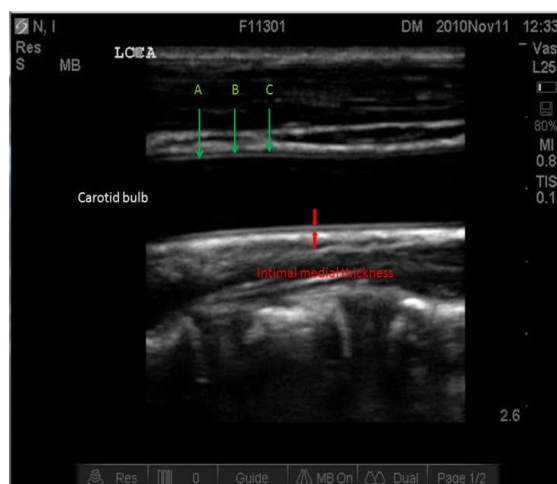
Ultrasound image of the left common carotid.
